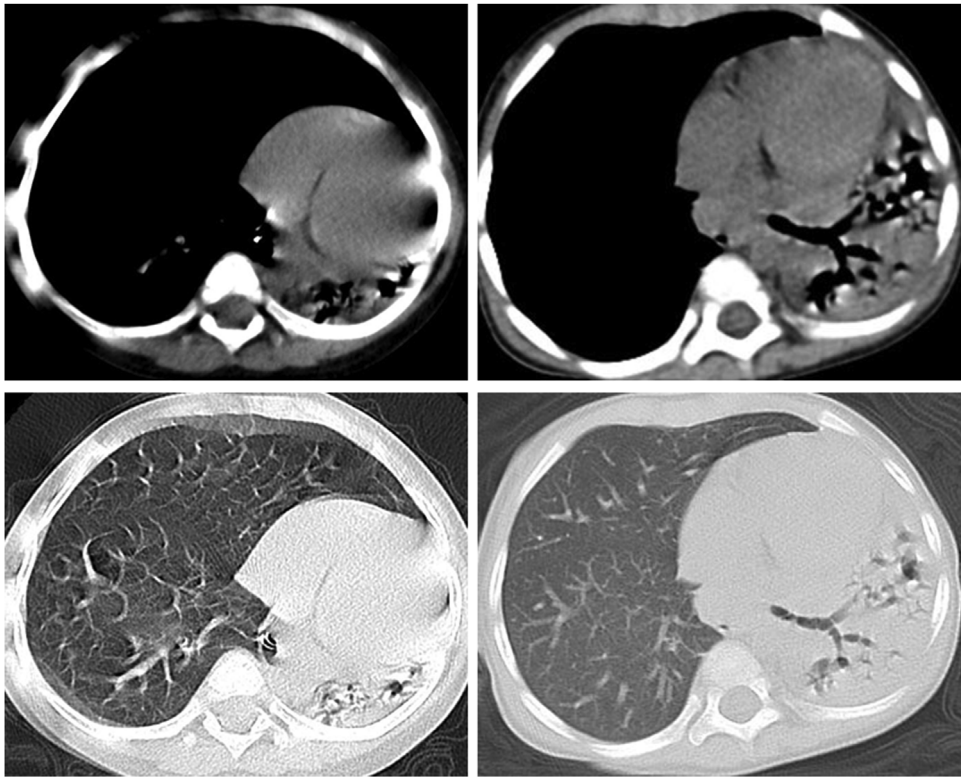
Computed tomography pre and post conservative management. Shrunken left lung after conservative management (lt) compared with its initial appearance (rt).
